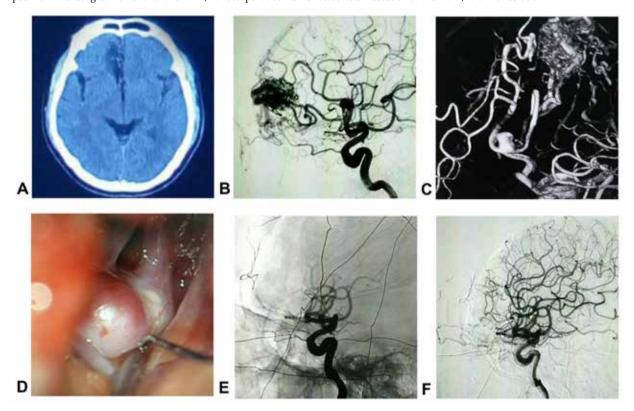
Image of Case 1 (Type II) A: Head CT showed low density in the right medial frontal lobe and what was considered a softened focus due to past hemorrhage; B-C: DSA and 3D reconstruction showed a frontal lobe AVM, which was mainly supplied by a branch of the anterior cerebral artery, and a berry aneurysm was observed at the beginning of the blood supply artery; D: A longitudinal fissure approach was adopted, and the aneurysm was located the beginning of the blood supply artery during the operation and then clipped; E-F: Postoperative DSA showed total resection of the AVM, and the artery was completely clipped.
